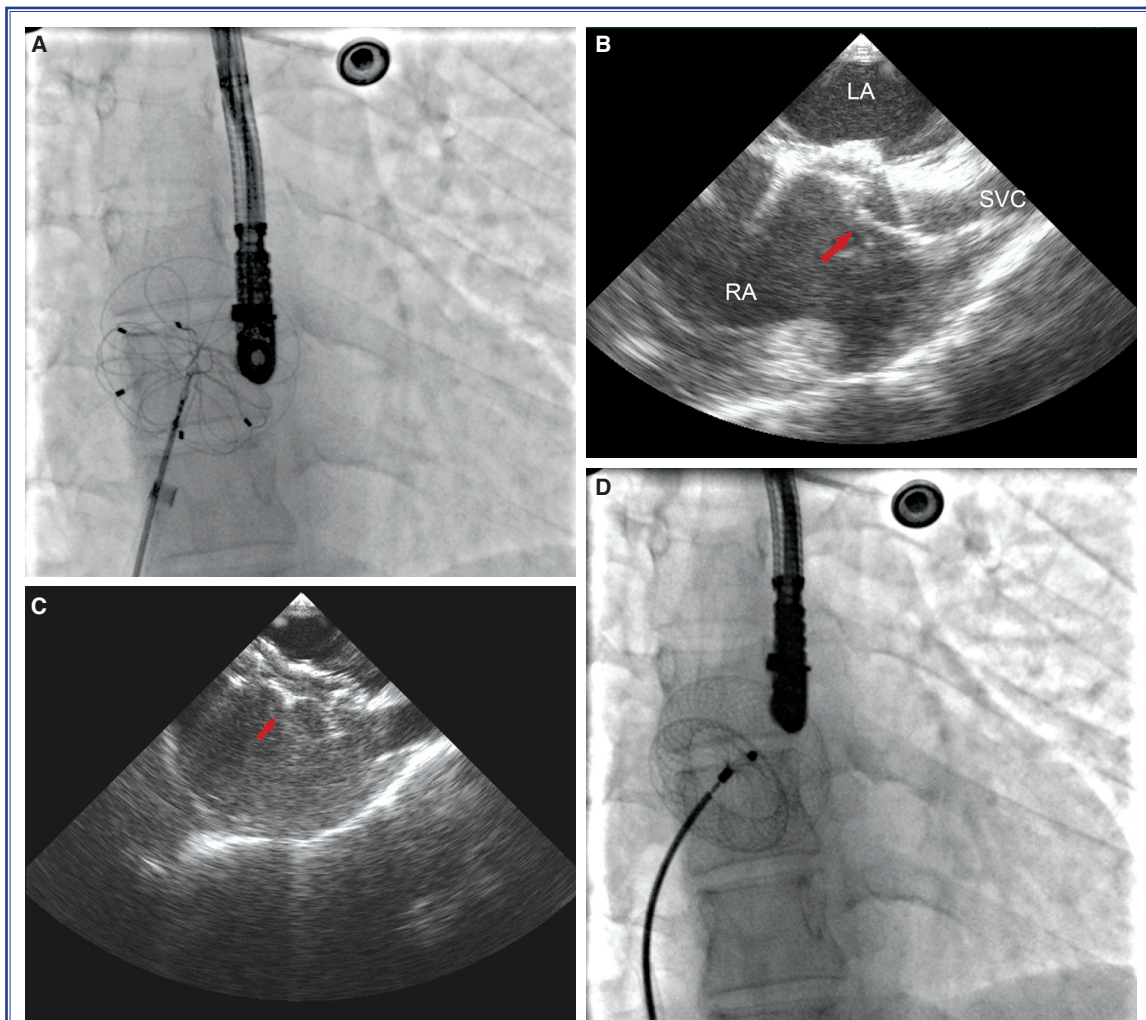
(A) Angiographic image demonstrating the Atriasept ASD occluder device after deployment of the right and the left atrial discs. (B) Transesophageal echocardiogram recorded at the bicaval plane revealing occlusion of the superior vena cava ostium with the right atrial disc (arrow) of the Atriasept ASD occluder. (C) Transesophageal echocardiogram recorded at the bicaval plane demonstrating the Amplatzer ASD occluder device (arrow) before its release from the delivery catheter and showing that the device is not obstructing the inferior or superior vena cava. (D) Angiographic image showing the Amplatzer ASD occluder before its release from the delivery catheter. LA: Left atrium; SVC: Superior vena cava; RA: Right atrium.
